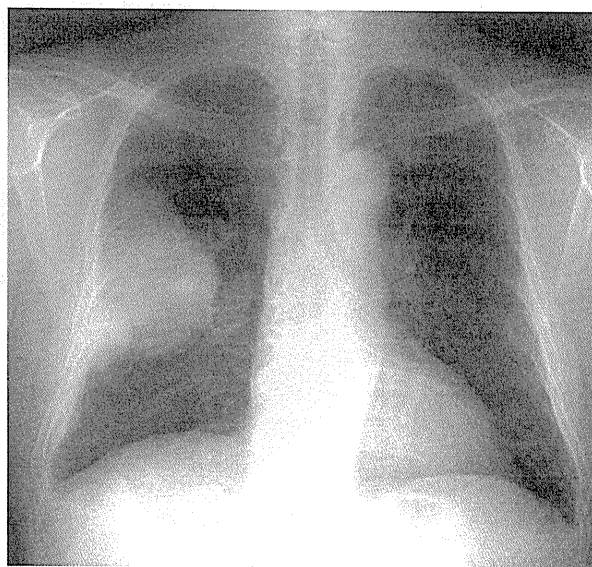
Chest radiograph showing well-defined tumor masses in the right hemithorax.
